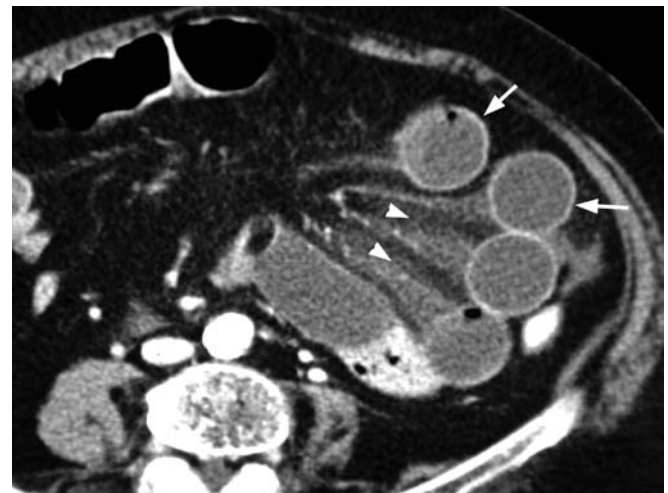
Strangulation ischemia of the small bowel due to adhesions. CT shows mild wall thickening (*arrows*) and mesenteric fat stranding (*arrowheads*). However, these findings are not absolutely specific for ischemia since they may be observed already in cases in which they represent only bowel wall edema resulting from venous congestion
